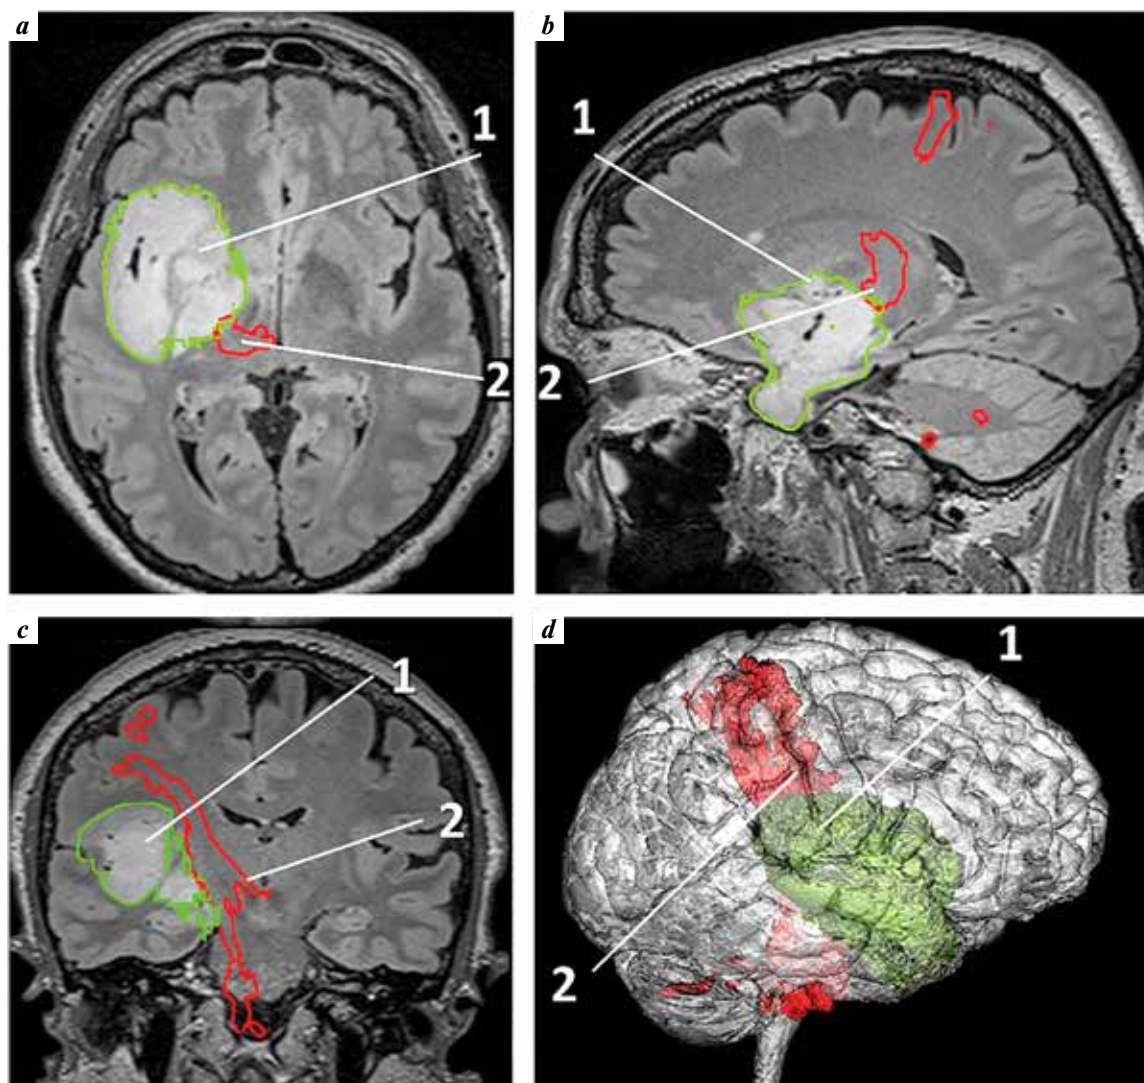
Magnetic resonance imaging (MRI) of brain for patient with diffuse astrocytoma (WHO grade 3) in right frontal, temporal and insular lobes with superimposed 3D models of corticospinal tract (CST) and tumor. Image in FLAIR mode: a – axial projection; b – sagittal projection; c – coronary projection; d – 3D combined model of the brain, tumor and CST in the StealthStation S7 navigation station. On the MRI series (FLAIR), a volumetric formation in the right frontal, temporal and insular lobes is determined, spreading into the subcortical nuclei on the right; adjacent to CST and partially dislocating it medially and posteriorly. The contours of the tumor (1) are marked in green, the CST (2) is marked in red
